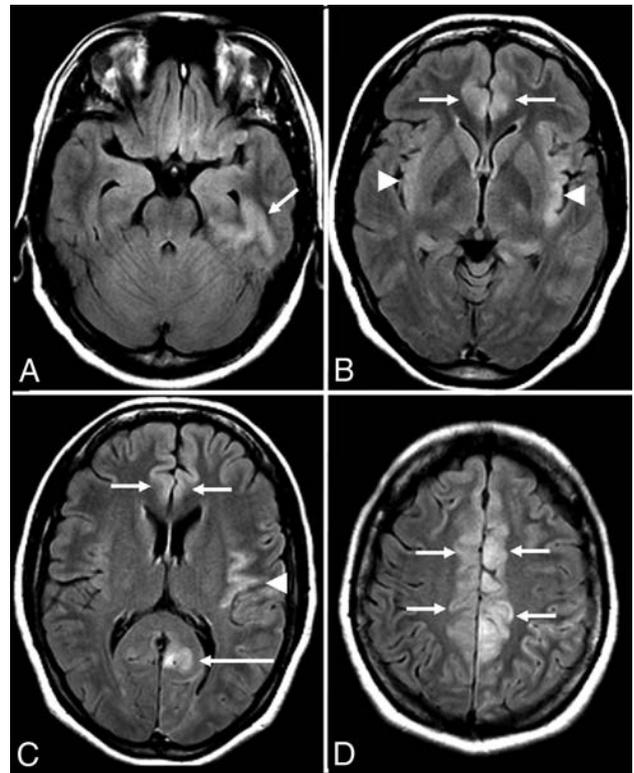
Anti-N-methyl D-aspartate receptor encephalitis. A 32-year-old woman presented with headaches, vertigo, and psychosis with subsequent development of encephalopathy and seizures. MR imaging of the brain performed after the onset of seizures 2 weeks after initial presentation demonstrates T2-FLAIR hyperintensity in the left inferior temporal lobe (A), left > right insular cortex (B and C), and left > right cingulate gyrus (B–D), without restricted diffusion (not shown), hemorrhage (not shown), or postcontrast enhancement (not shown).
